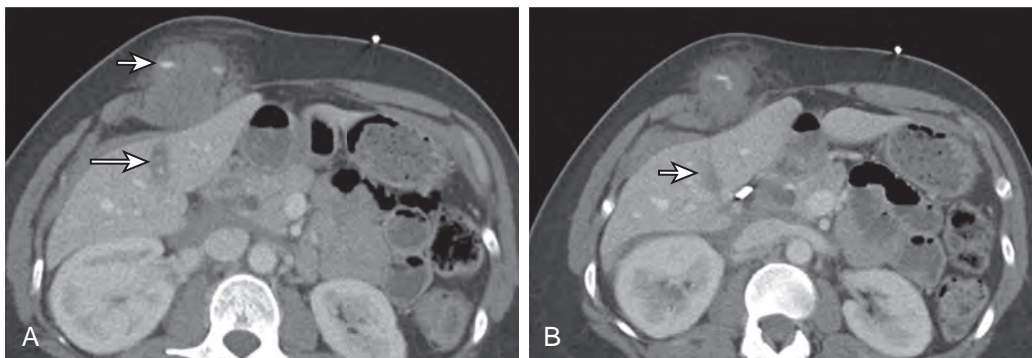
Patient with a penetrating injury from a stab wound with a 5-inch steak knife while in the shower. A. Within the abdominal wall, a hematoma from the stab wound is seen with a blush of contrast material, suggesting active extravasation (short arrow). A liver laceration is also identified (long arrow). B. CT image demonstrates the extent of the laceration through the left lobe of the liver (arrow).
